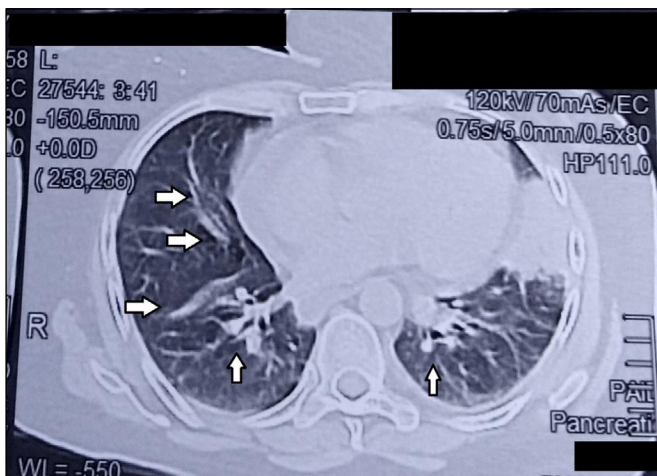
High-resolution computed tomography (HRCT) showing bilateral lower lobes with fibrotic changes (multiple white arrows).
